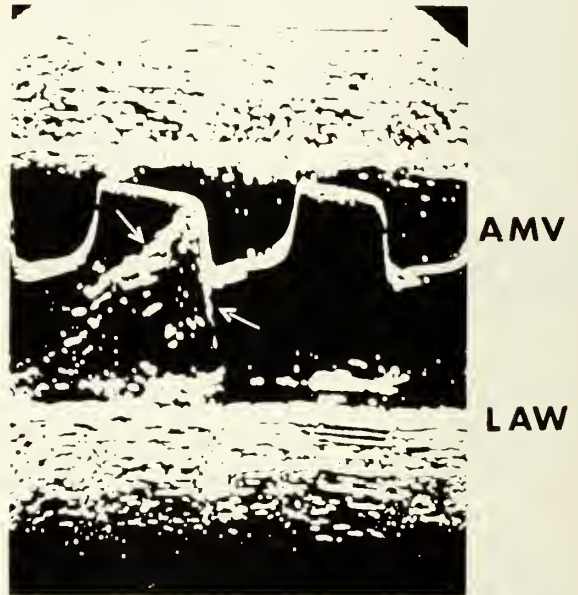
Echocardiogram in a patient with mitral stenosis and atrial fibrillation. A large mass of echoes (arrow) can be seen intermittently below the valve representing a large mobile atrial thrombus. This was confirmed angiographically and was surgically removed.
